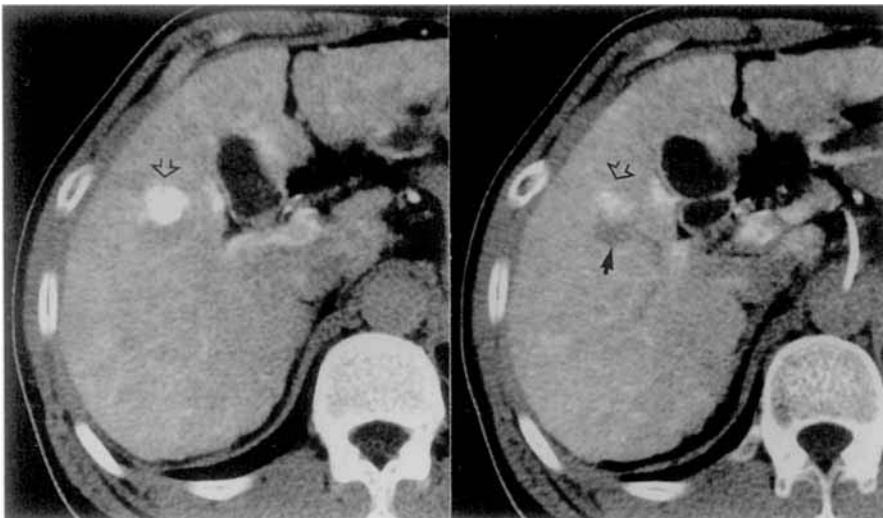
CT arteriography reveals a hyperattenuated component (arrowhead) and a surrounding hypoattenuated area (arrow).
